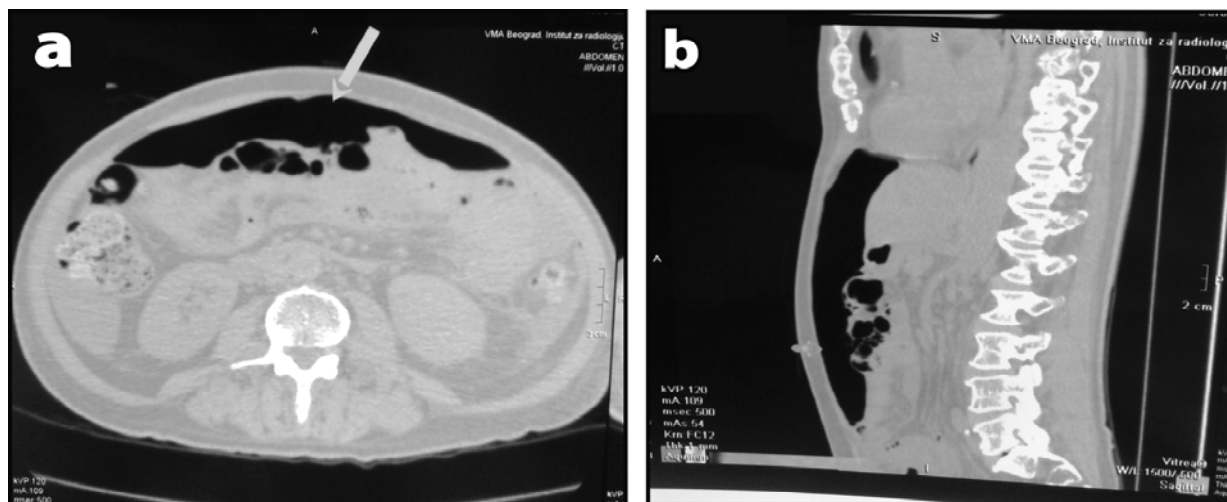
Pneumoperitoneum in a patient with non-Hodgkin lymphoma on a) transversal and b) longitudinal section of chest and abdominal multislice computed tomography.
